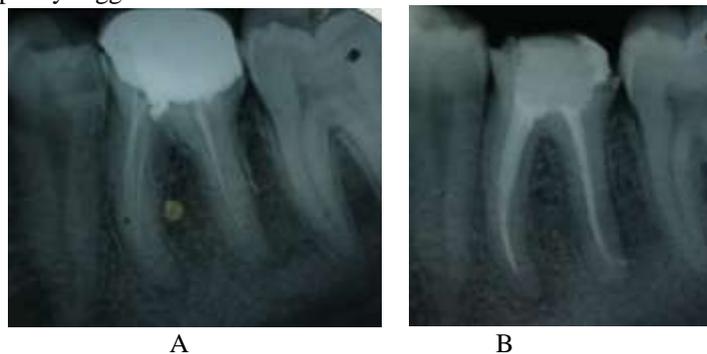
Pre-operative (A) and Postendodontic (B) radiograph of #36 showing retreatment of the tooth.
